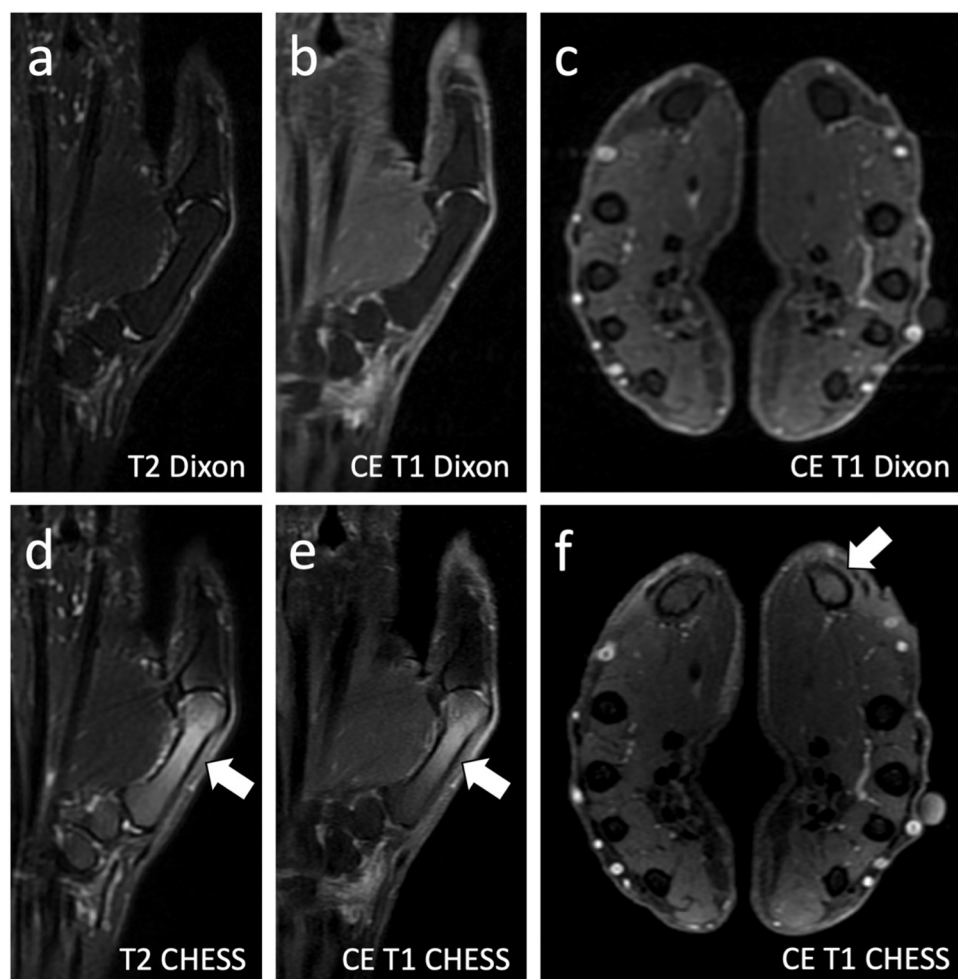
Comparison between Dixon- (a–c) and CHES-based (d–f) images of the right thumb of a 59-year-old RA patient. Fat suppression was effective on all Dixon images, including (a) T2-weighted Dixon water-only and contrast-enhanced 2D SE T1-weighted Dixon water-only images in the (b) coronal and (c) axial planes. Fat suppression failure occurred on all CHES images (arrows) including (d) SE T2-weighted CHES and contrast-enhanced 2D SE T1-weighted CHES images in the (e) axial and (f) coronal planes.
